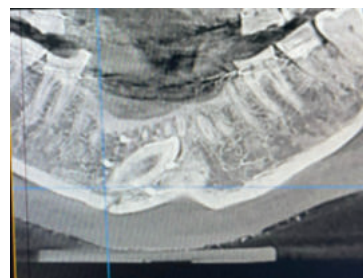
depicts position of screws on a computed tomography scan on immediate post operative day.
